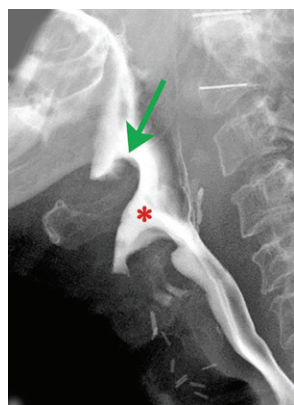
Incomplete epiglottis tilt in a 72-year-old man. Lateral radiograph shows a swelling epiglottis in upward position during the bolus passage (arrow). As a consequence of the insufficient tilt of the epiglottis, a partial obstruction of bolus displacement and penetration of contrast material into the laryngeal vestibule (*) are visible.
